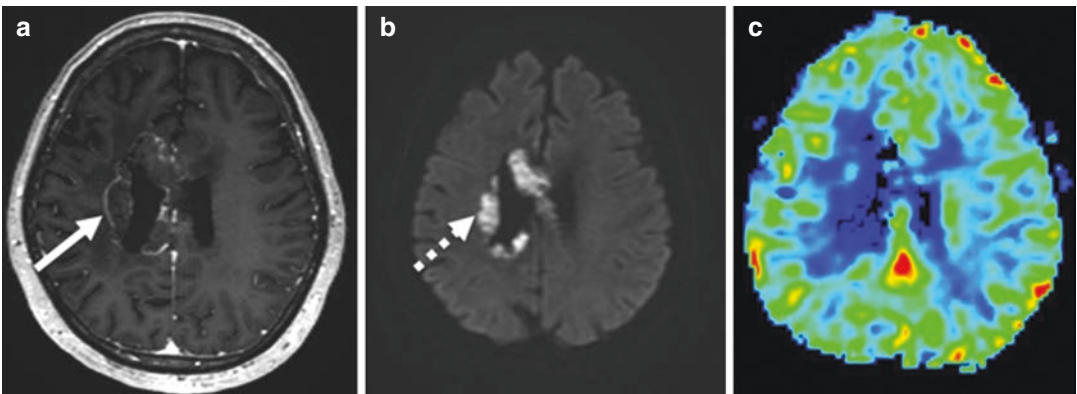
Bevacizumab-related imaging abnormality (BRIA) associated with glioblastoma necrosis. Following treated with bevacizumab, (a) contrast T1-weighted image demonstrates thin rim-enhancement, (b) marked internal
